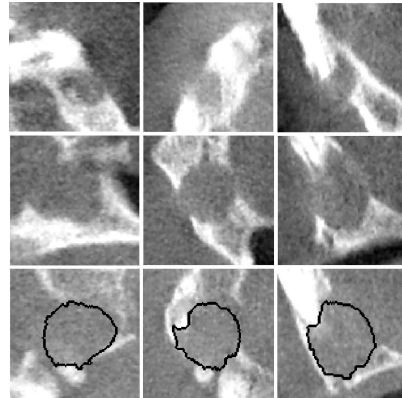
Example of periapical lesions and 3D segmentation by the random walks algorithm. Sagittal, coronal, and axial view of a granuloma (top) and a cyst (middle) are displayed. Visually, they are hard to differentiate. Bottom row shows an example of 3D segmentation by our method.
